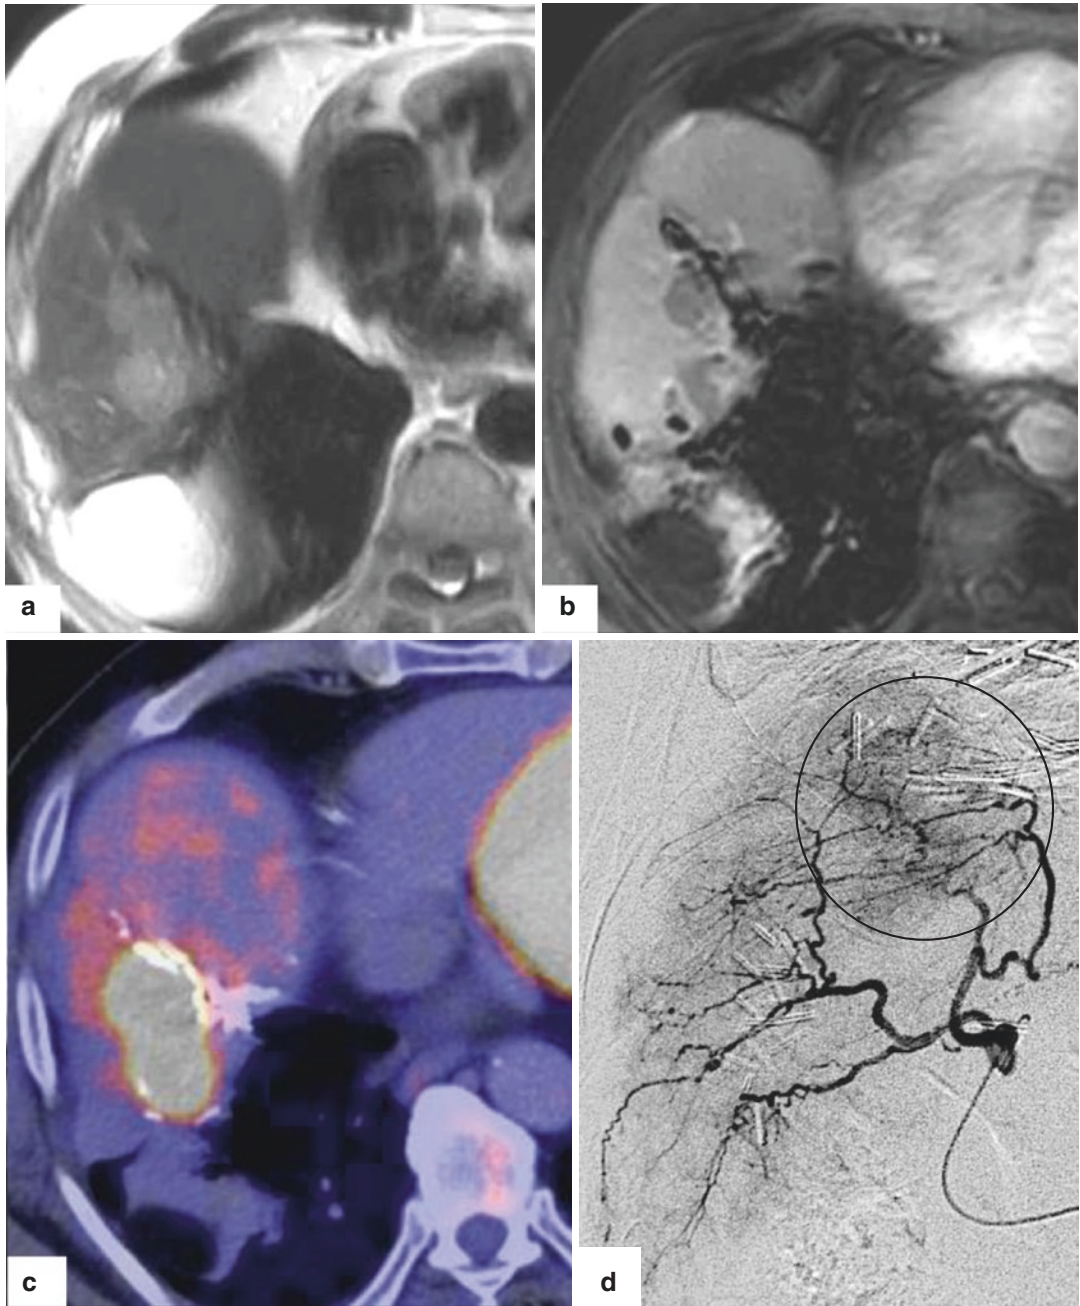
Seventy-eight-year-old male with recurrent isolated CLM in segment VIII despite previous surgery and two lines of chemotherapy. (a) T2-weighted MRI. (b) Gadolinium-enhanced MRI. (c) PET-CT. (d) Selective angiography of segment V and VIII shows tumor enhancement (*circle*). (e) Intra-arterial CBCT confirms tumor enhancement in segment VIII (*dotted circle*). (f) MAA
